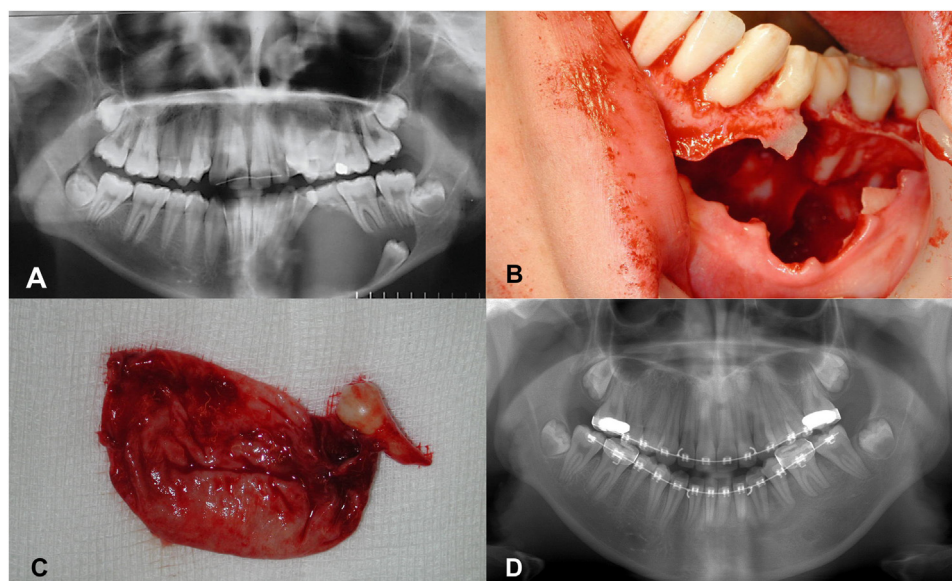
An example of an odontogenic keratocyst: A, An orthopantomogram showing a unilocular radiolucency occupying the mandibular left body and parasymphysis with the expansion of the jaw, a displaced adult premolar can also be seen; B, An intraoral photograph of the mandibular left cyst cavity after enucleation; C, A photograph of the enucleated cyst with adult premolar tooth; D, An orthopantomogram showing bony infill of the cyst cavity and fixed orthodontic appliances.
